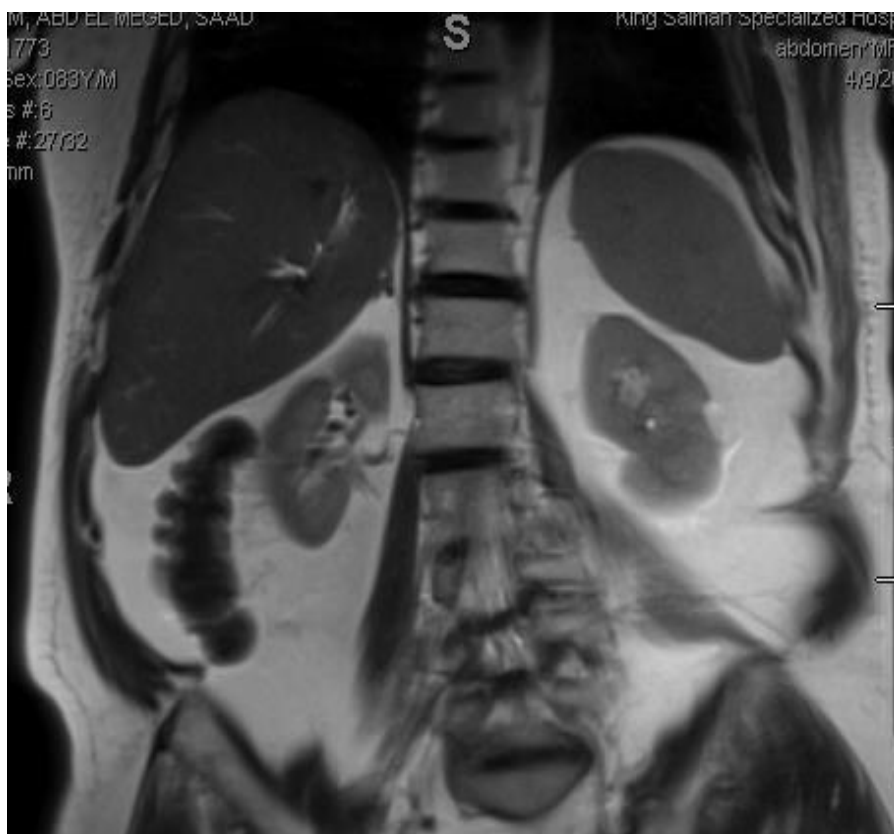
abdominal MRI after six months showing complete resolution of the abscess
